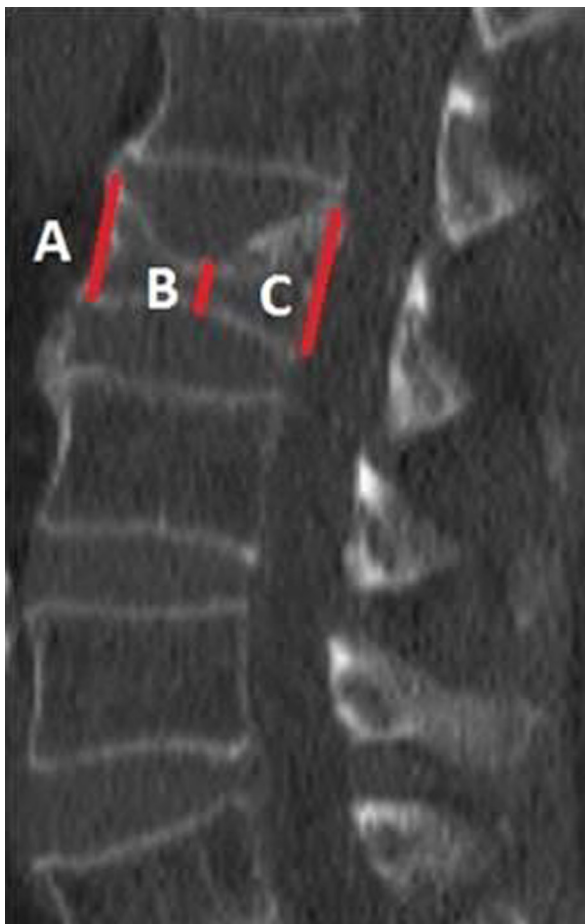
Exemplary case images (Preoperative (a) anterior, (b) midline and (c) posterior heights, sagittal CT)
